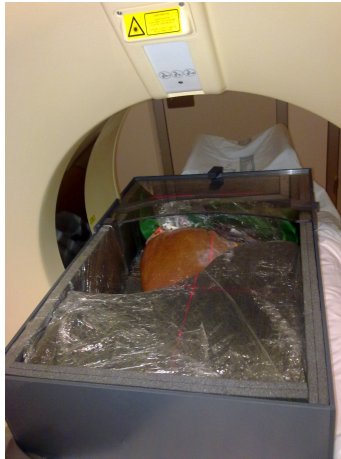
CT image acquisition of an in vitro human liver with Brilliance iCT Philips in the Hospital Universitari i Politècnic La Fe de Valencia. Two image acquisitions were performed (end-exhale and end-inhale) using the AHT.*
